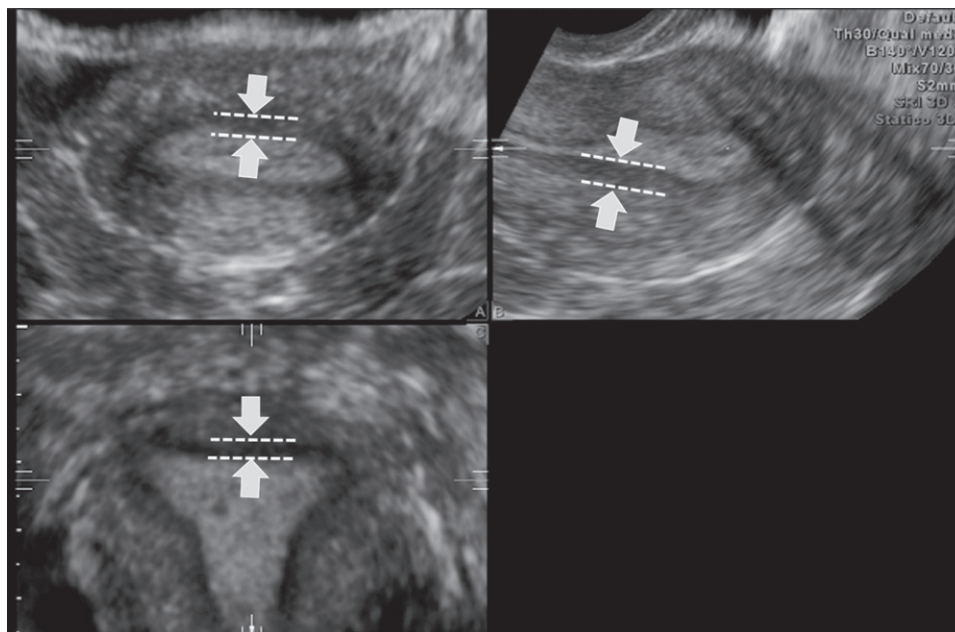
Multiplanar view of the uterine corpus obtained by three-dimensional ultrasound. The junctional zone (JZ) can be seen as a dark line just beneath the endometrium (arrows and dashed lines). The JZ of the anterior and posterior wall is visualized in the A- and B-planes and the JZ of the left and right lateral walls and of the fundus in the C-plane.
